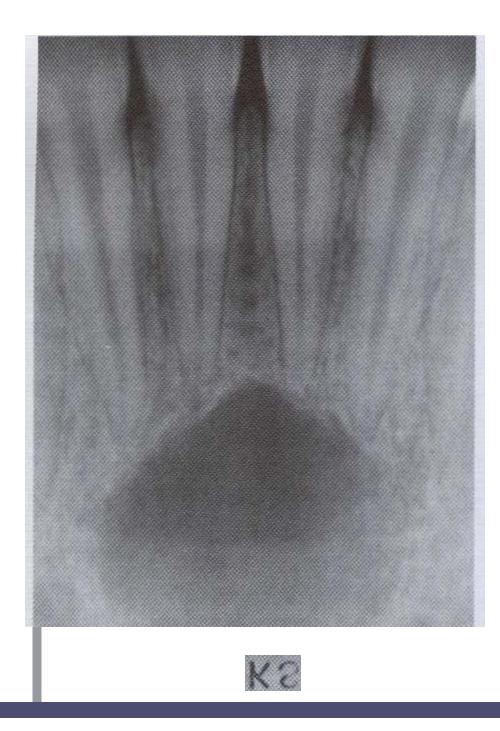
• Simple bone cyst. Periapical radiograph showing a radiolucent area in the apical region of the anterior mandible. The incisor teeth responded normally to vitality testing, and no restorations are present.
